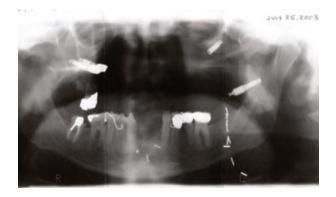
Panoramic radiograph of 2 right Calcitek and 2 left Nobel Biocare implants.
